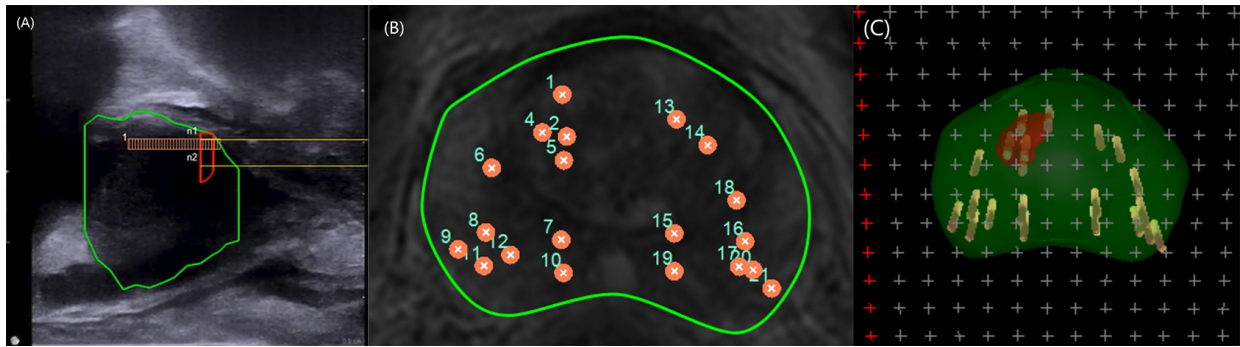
Record of biopsy trajectory. A sagittal view of ultrasound revealed a biopsy trajectory through the target lesion (A). All targeted and systematic biopsy trajectories were recorded on a 2-D or 3-D model (B,C).
